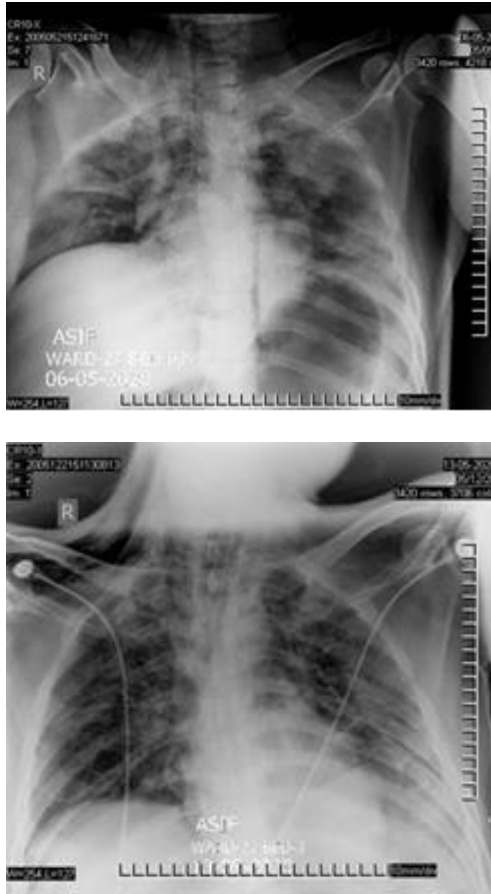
Chest Radiographs of the patient on days 8 and 15 after the onset of illness. Endotracheal tube was instituted and mechanical ventilation provided in the period between the acquisitions of two images. Bilateral multifocal patches of consolidation with air bronchogram and ground glass haze appearance seen in Image 1 showing improvement of lung expansion in post intubation Image 2.
